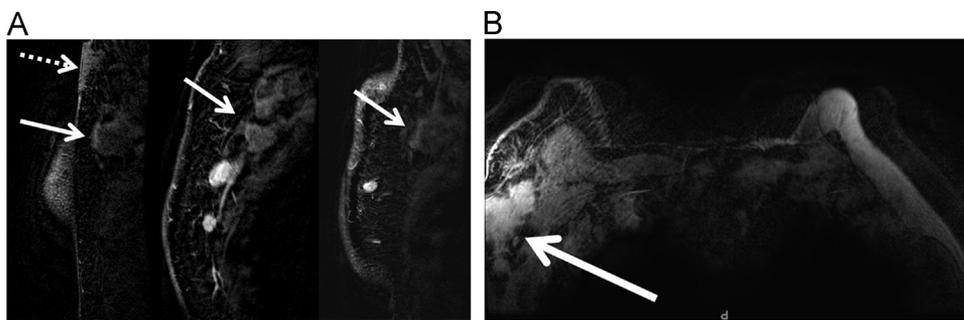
A 65-year-old male with known right breast cancer underwent breast MRI for evaluation of extent of disease. Sagittal T1-weighted post-contrast MRI with fat suppression from lateral to medial of the right axilla (from left to right) (A) and axial T1-weighted fat suppressed post contrast (B) image demonstrate extensive right axillary lymphadenopathy (solid arrows), some of which are necrotic. There is also abnormal skin enhancement (dotted arrow) due to skin involvement by the cancer.
